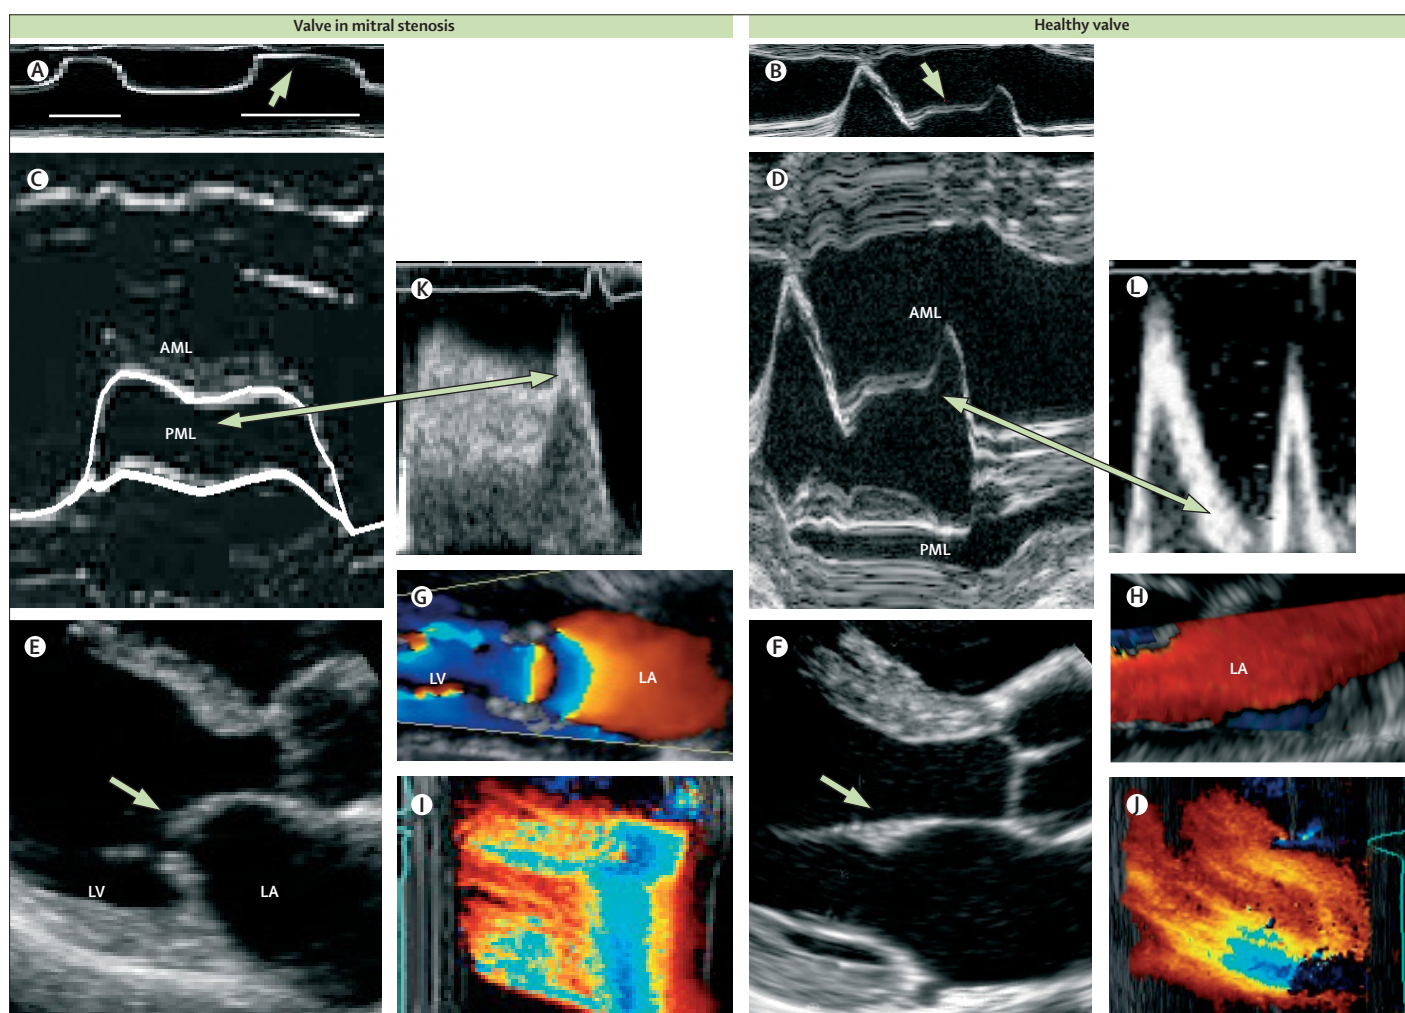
Echocardiogram of mitral stenosis
